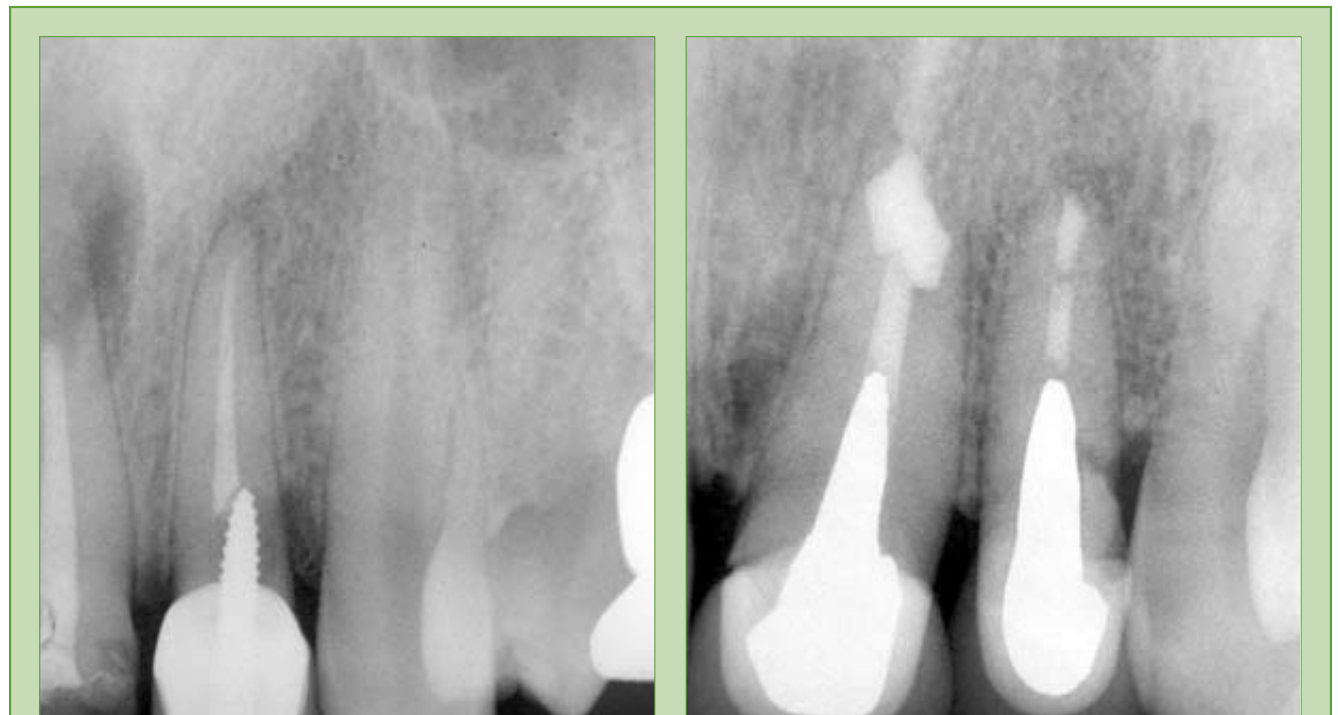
Initial radiograph showing periapical pathology and tooth with guarded prognosis (1994).
